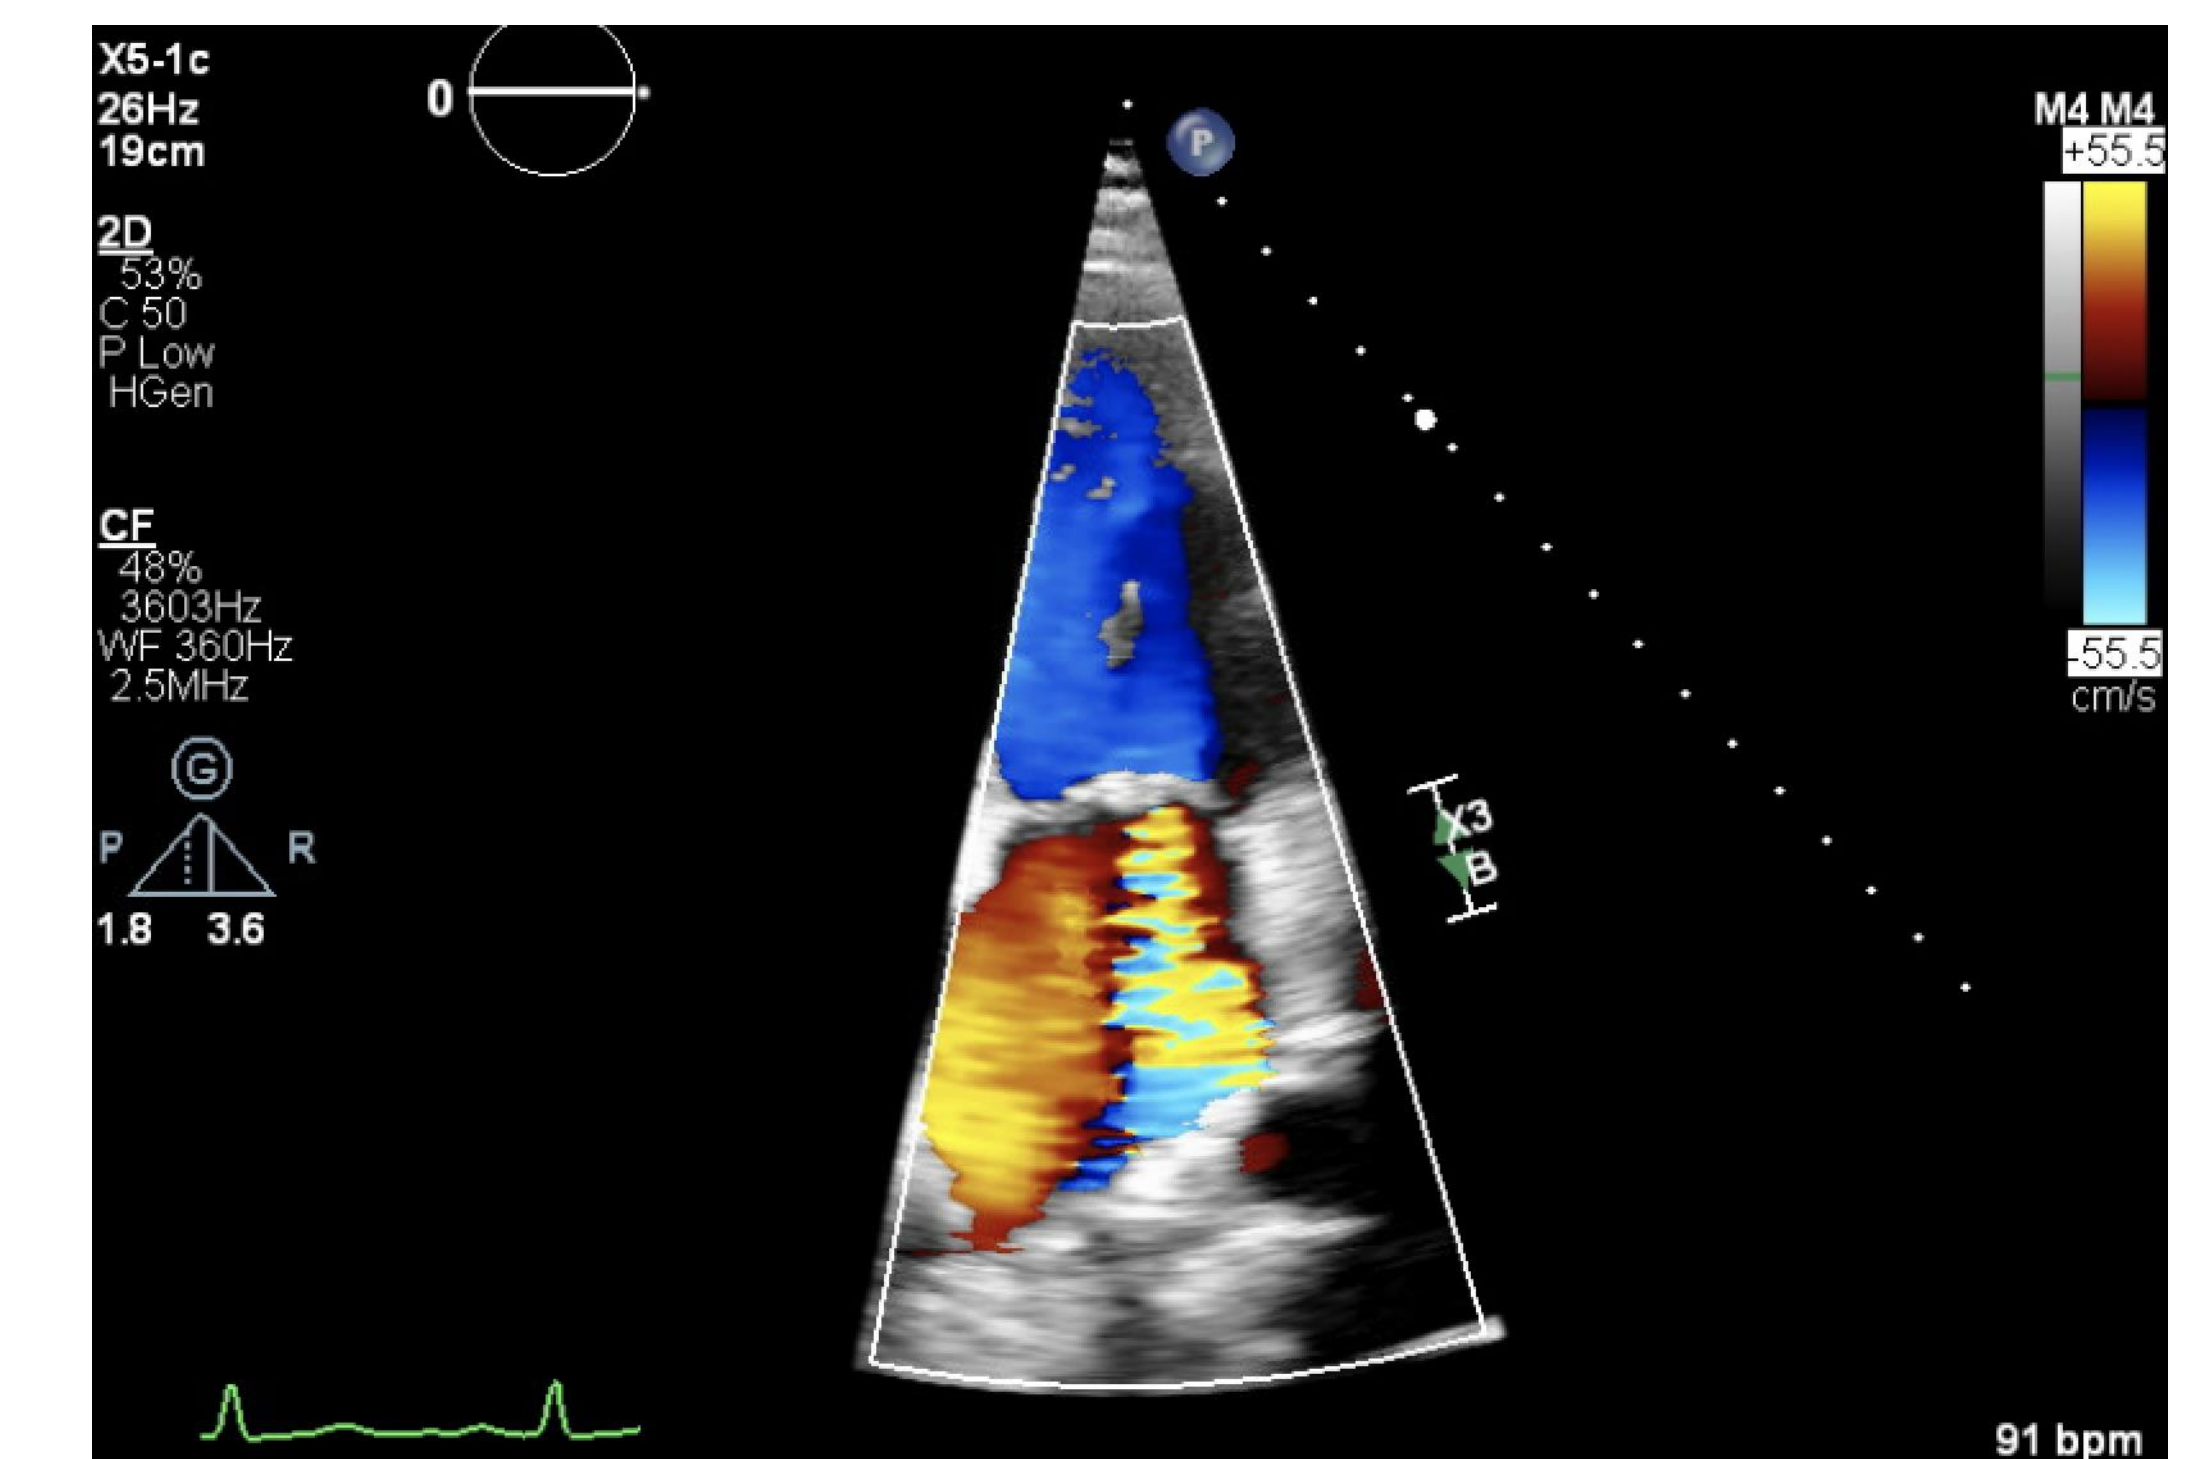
Apical four-chamber view of mitral valve
